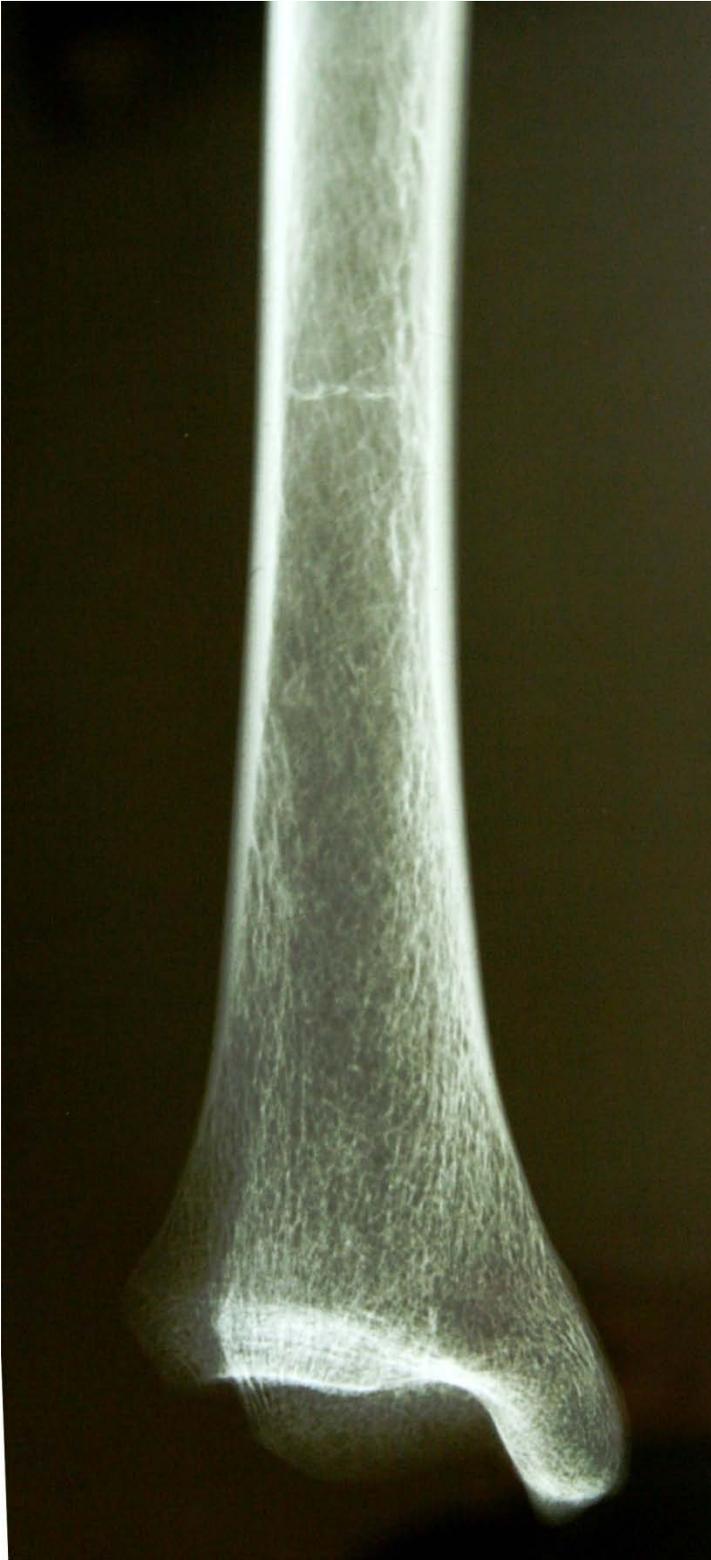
Radiograph of a tibia with a Harris line
